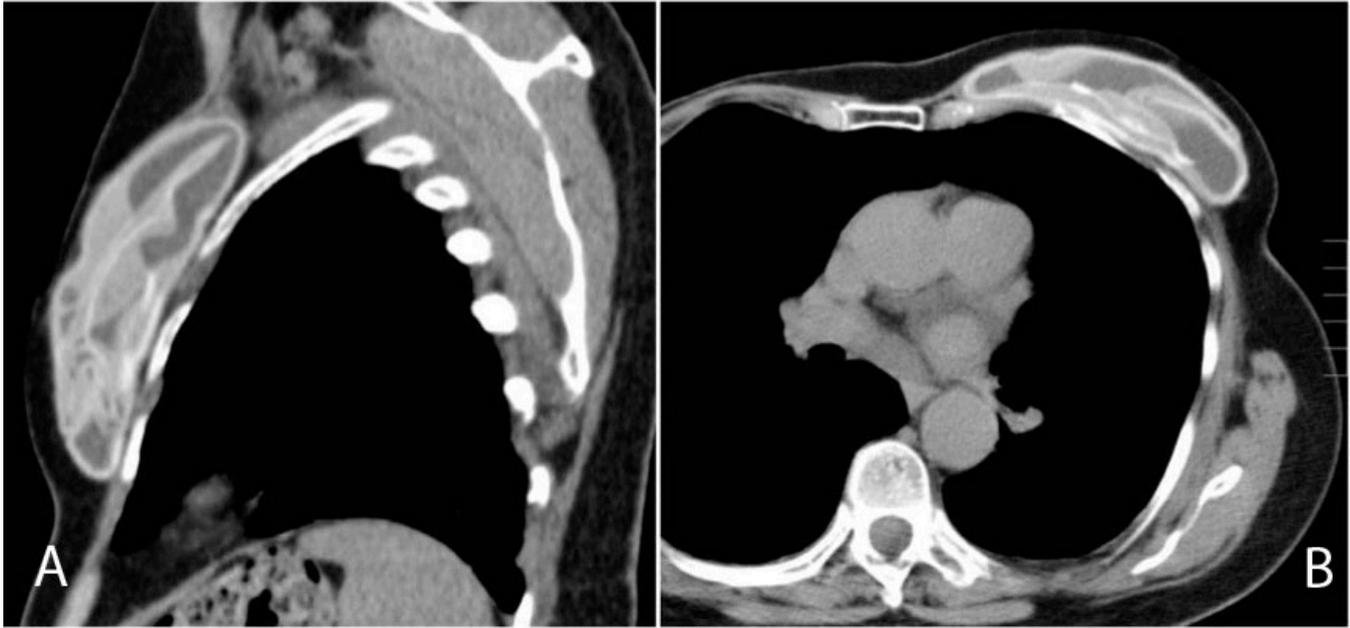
Sagittal (A) and axial (B) noncontrast CT images showing ruptured left silicone breast implant.
